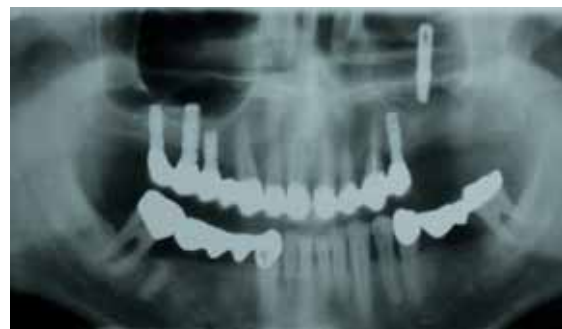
Panoramic radiograph showing the implant displaced into the maxillary sinus.
